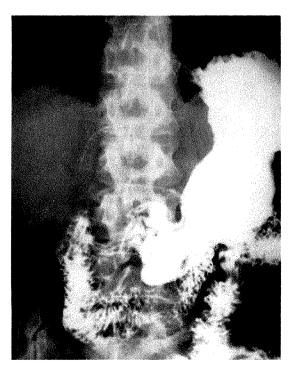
Posteroanterior recumbent upper gastrointestinal roentgenogram showing a calcified structure to the right of the lumbar spine in the region of the porta hepatis.
